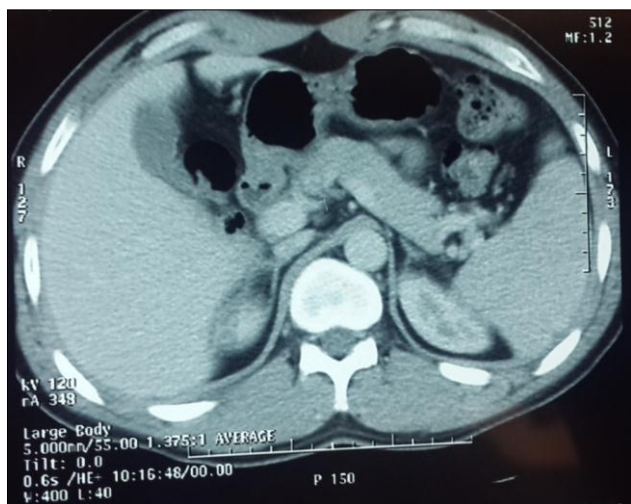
CT scan of the normal spleen
